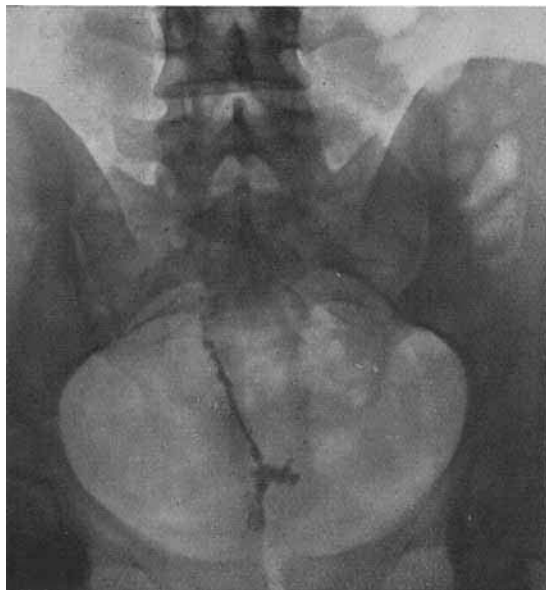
Case 1. X-ray photograph showing the sinus after a lipiodol injection. The upper narrow portion is the secondary sinus, the lower expanded portion the primary sinus in the median raphe.
